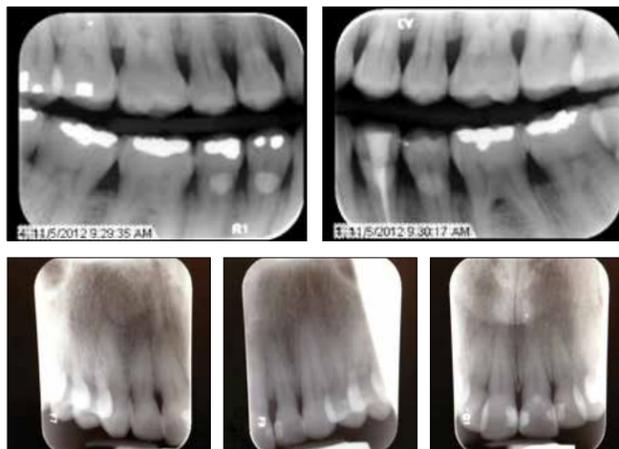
Patient's radiographs show mild bone loss on teeth #4 - #13.
